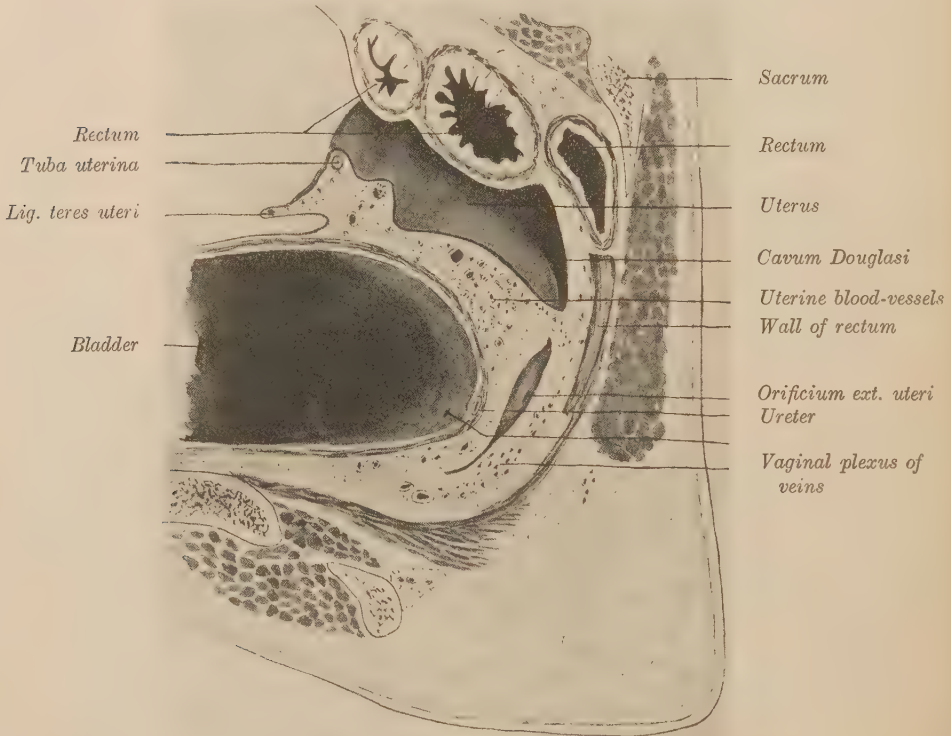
PART OF A SAGITTAL SECTION OF THE PELVIS OF A WOMAN AGED THIRTY-SIX YEARS, MADE 3 CM. TO THE RIGHT OF THE MEDIAN PLANE AND VIEWED FROM THE MEDIAN ASPECT. Two-thirds natural size. (J. Symington.)
